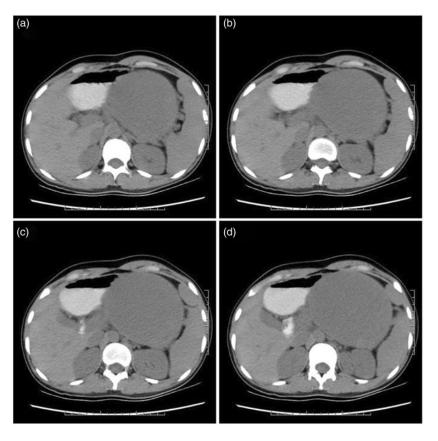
Preoperative non-contrast computed tomography scan showed a huge tumor.
